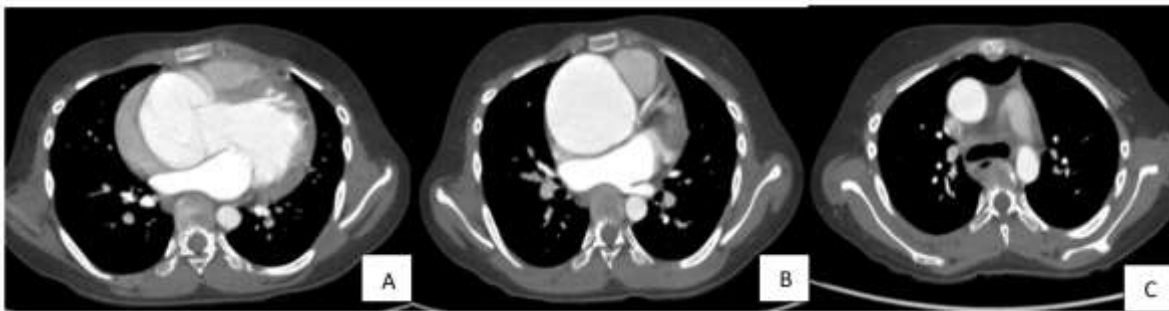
15-year-old with chest pain and breathlessness, diagnosed as fusiform aneurysm of ascending aorta. Depicted CT images showing A. Axial post-contrast image at the level of the aortic valve, revealing a dilated aortic root. B. Axial image displaying fusiform aneurysmal dilatation of the ascending aorta. C. Axial image of the same patient depicting normal calibres of the ascending and descending aorta at a level above the aneurysm.
